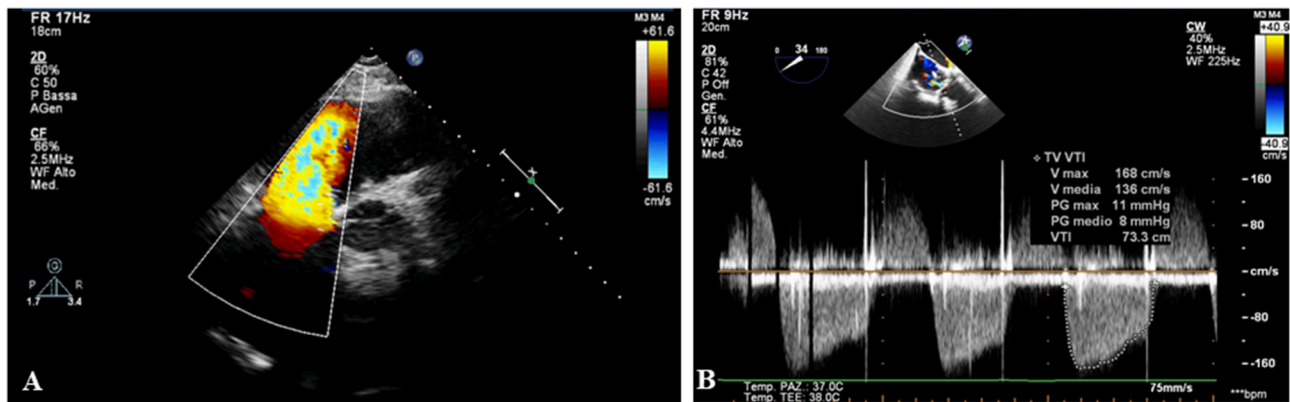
The echocardiography shows a degeneration of tricuspid biological prosthesis with severe regurgitation (A) and stenosis (B).
